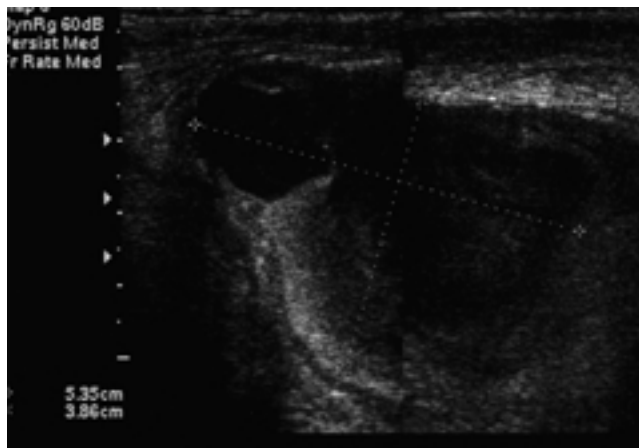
Ultrasonography reveals a large pseudoaneurysm with partial thrombosis.
